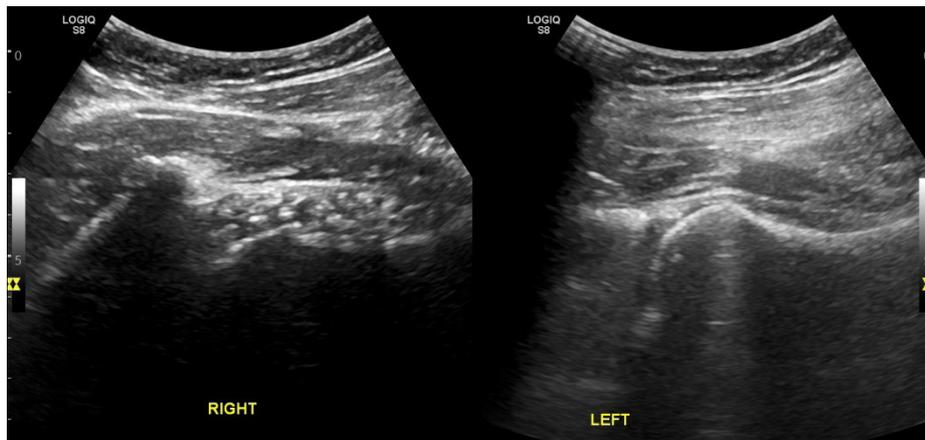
Ultrasound examination of the hip joint. Intra-articular loose bodies in the right hip joint
